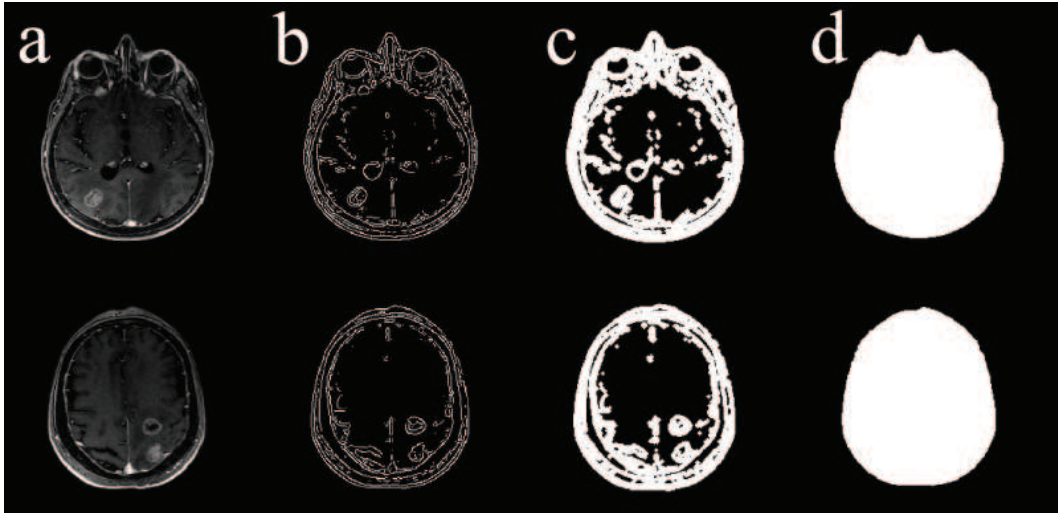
Binary head formation steps for two different axial slices: a)Original MRI Slice, b)Canny edges, c)Dilated canny edges, d)Obtained head mask.
